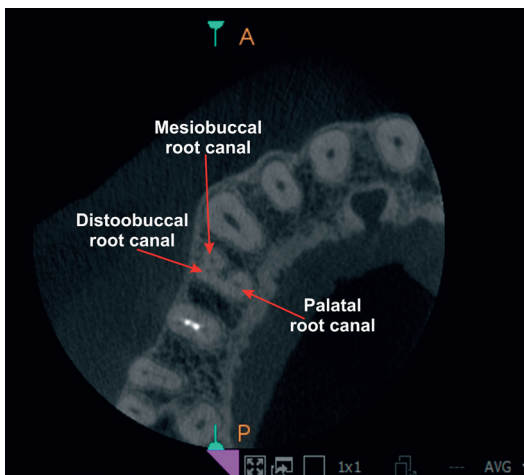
Cone beam computed tomography scanning in the horizontal plane of the middle third of the root-tooth 14
